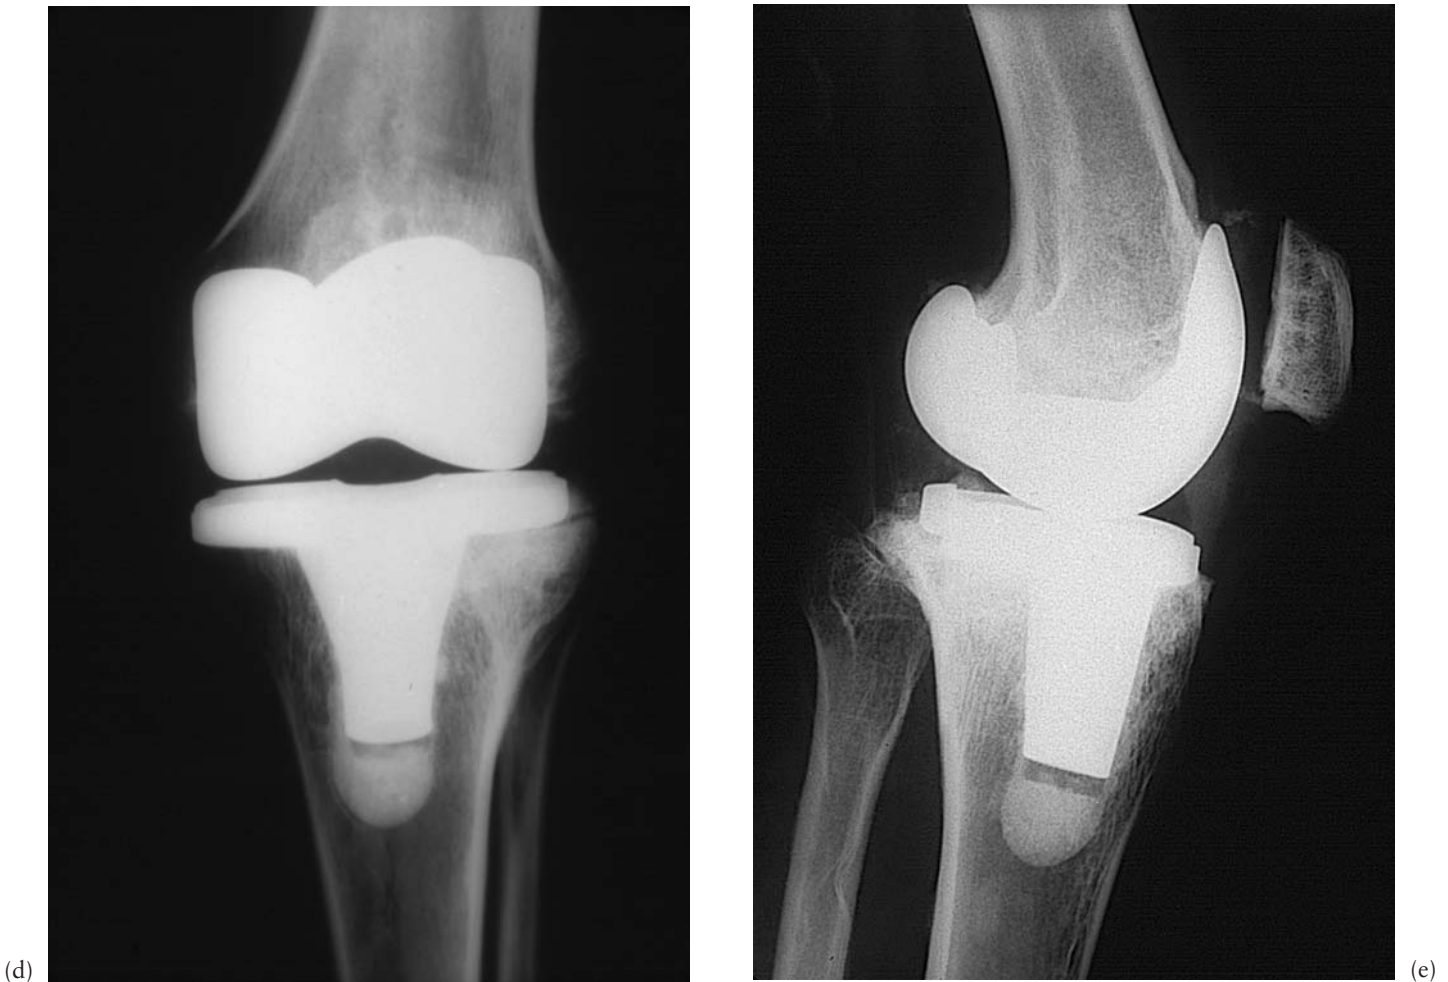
(cont'd) (d) AP radiograph at 5 years; and (e) lateral view at 5 years. The result was excellent.
